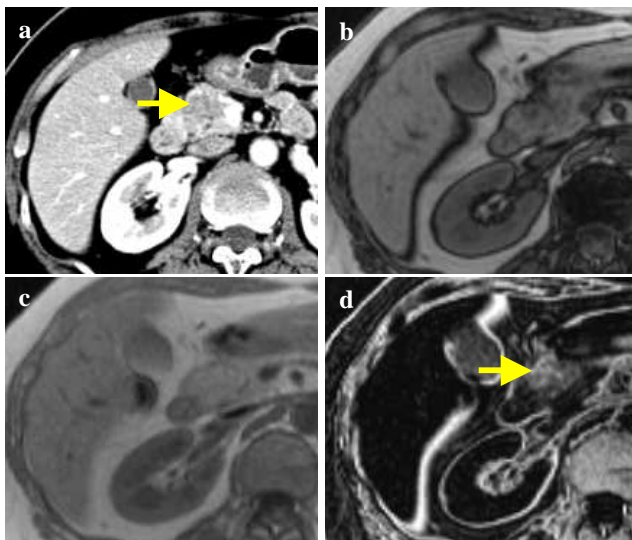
Focal fatty change of the pancreas. (a) Arterial-phase CT shows an equivocal lesion with slightly hypo-attenuation (arrow) in the pancreatic head. (b) Opposed-phase GRE image. (c) In-phase GRE image. (d) Subtracted fat image shows the lesion with high signal intensity (arrow) in the pancreatic head, indicating focal fatty change of the pancreatic head.
